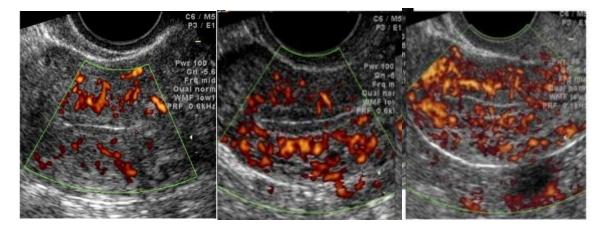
Doppler blood flow in zone II, zone III, and zone IV.
